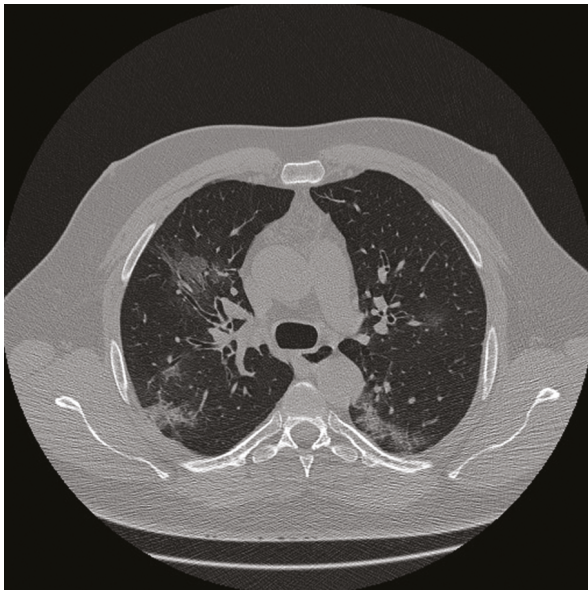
Chest CT-scan shows some areas of ground glass with widening of the vessels and consolidation in the posterior parts of the lobe
